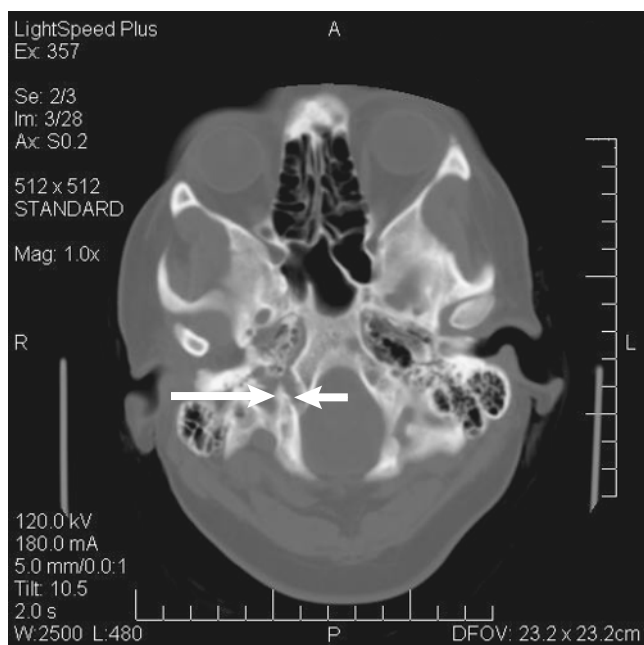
Axial computed tomographic scan of the hypoglossal canal (short arrow) in close proximity to the jugular foramen (long arrow).
